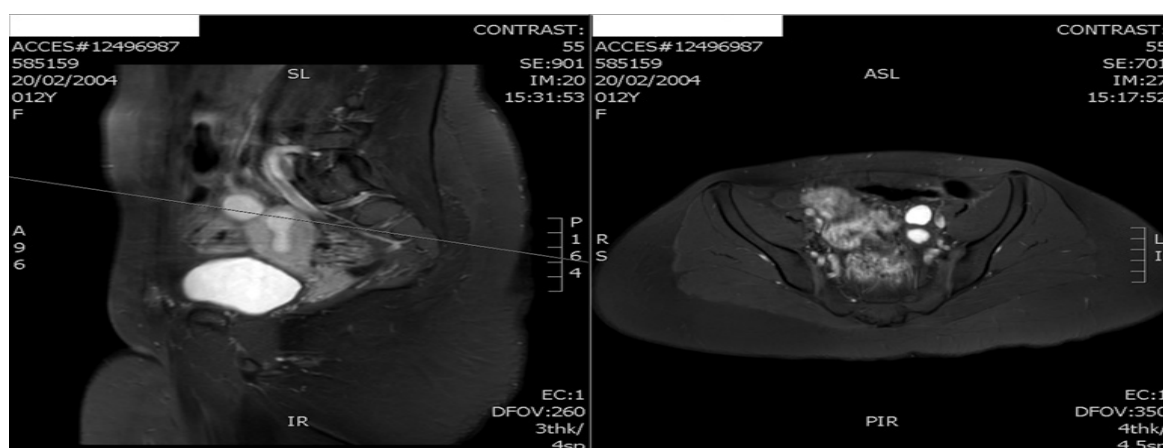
MRI images showing an elliptically shaped uterus (solitary cornua) deviated to the left side with normal myometrial and endometrial differentiation (A). Non-communicating horn is next to it also with endometrial and myometrial communication (B). The absence of connection between the upper vagina and the uterus – length of the non-communicating segment is 2.5cm (C). Normal vagina with a length of 4.5cm with no septum (D).
